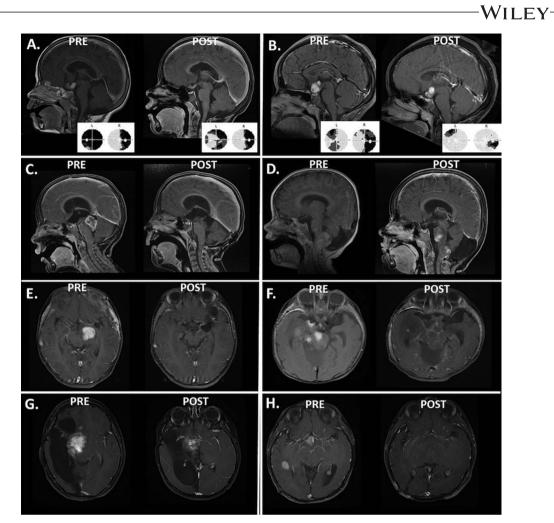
Radiographic response of recurrent/refractory LGG to single-agent bevacizumab. Post gadolinium T1 sequences reveal radiographic responses post bevacizumab therapy for Patient 7 (A), Patient 11 (B), Patient 14 (C), Patient 9 (D), Patient 12 (E), Patient 3 (F), Patient 2 (G), and Patient 5 (H). Improvements in formal visual field testing were seen in Patients 7 (A) and 11 (B)
